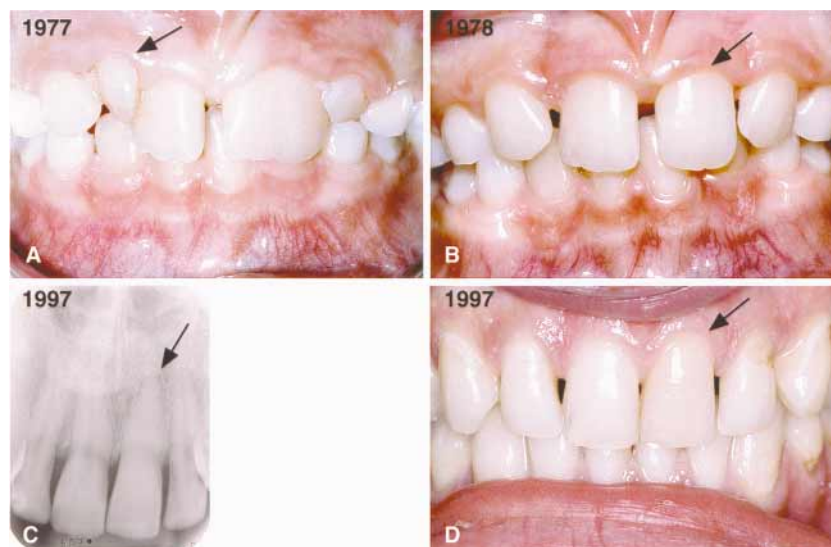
Transplantation in 1977 of supernumerary maxillary right lateral incisor (arrow in A) to replace malformed (fused) maxillary left central incisor (A, B). No orthodontic treatment was performed. Radiograph 20 years after transplantation (C) shows normal periradicular appearance and pronounced obliteration of root canal (arrow in C). Marked obliteration may explain why transplanted incisor (arrow in D) has more yellowish color than do neighboring incisors.
